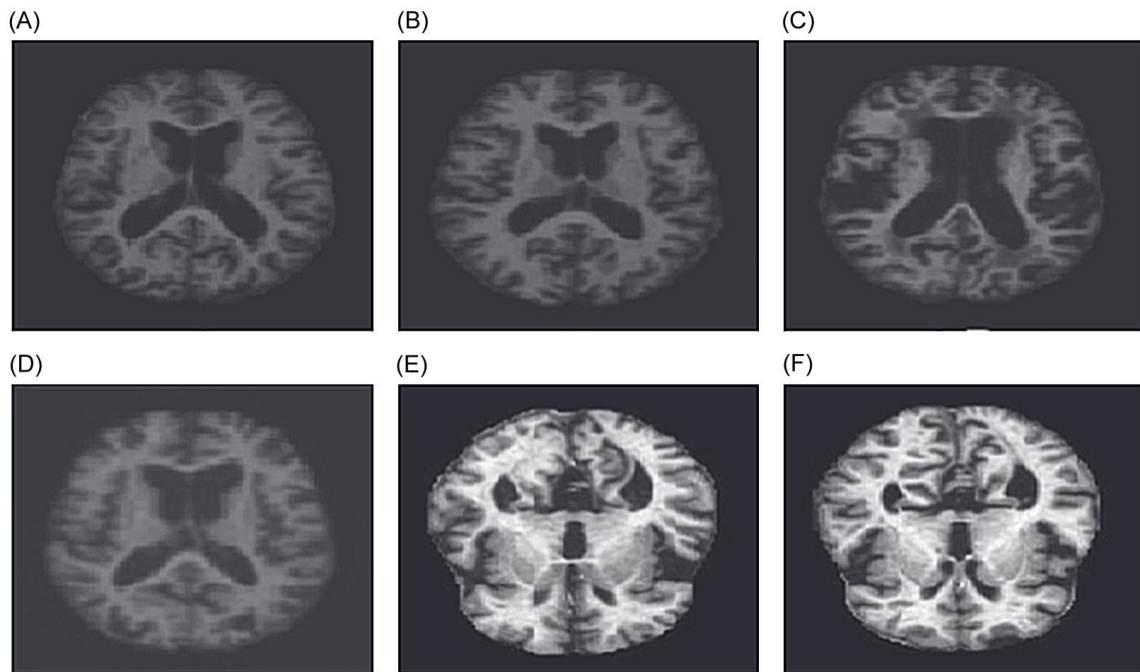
MRI images from OASIS dataset: (A) non-demented aging disease, (B) high-grade mild dementia, (C) mild dementia disease, (D) less extreme dementia disease, (E) Alzheimer's Disease, and (F) healthy control [26].
